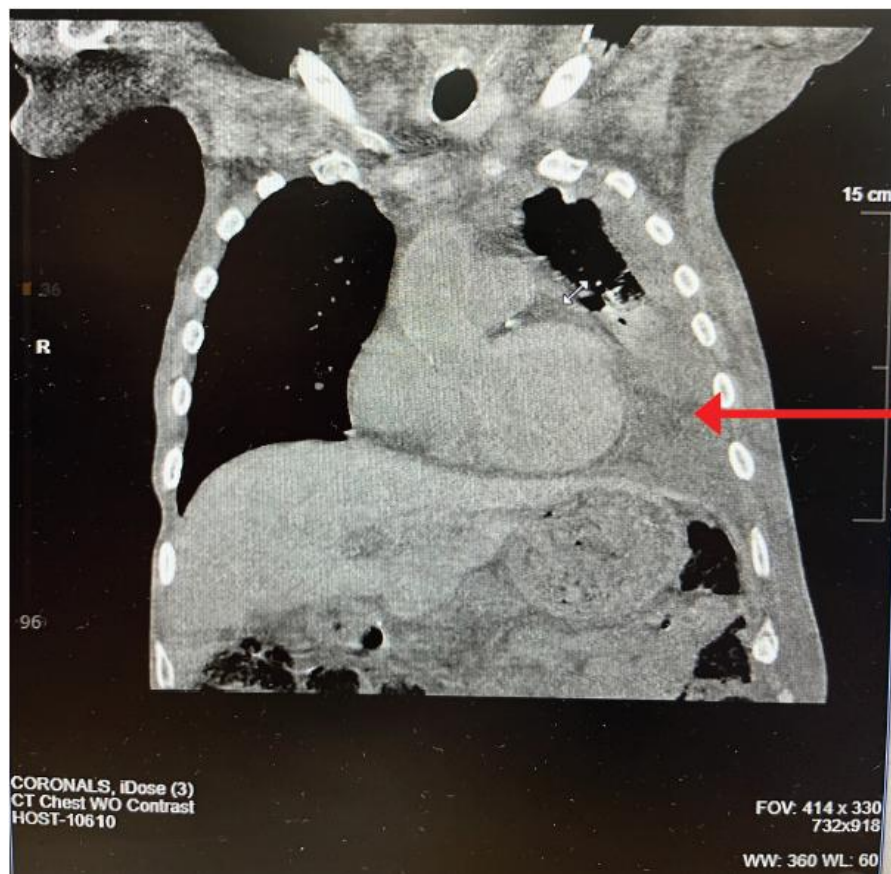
Coronal non-contrast CT chest demonstrating a large left-sided pleural effusion.
